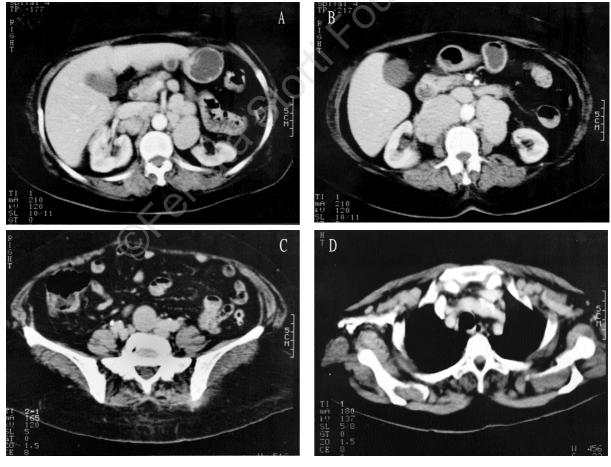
A, Abdominal CT after i.v. contrast agent administration shows multiple retroperitoneal lymph nodes in the periaortic site, around the renal vascular peduncle and the celiac tripod, B, in the retroperitoneum, C, in the presacral region; D, many small nodes are also demonstrated bilaterally in the anterior chest wall, above the superficial pectoral muscle.
